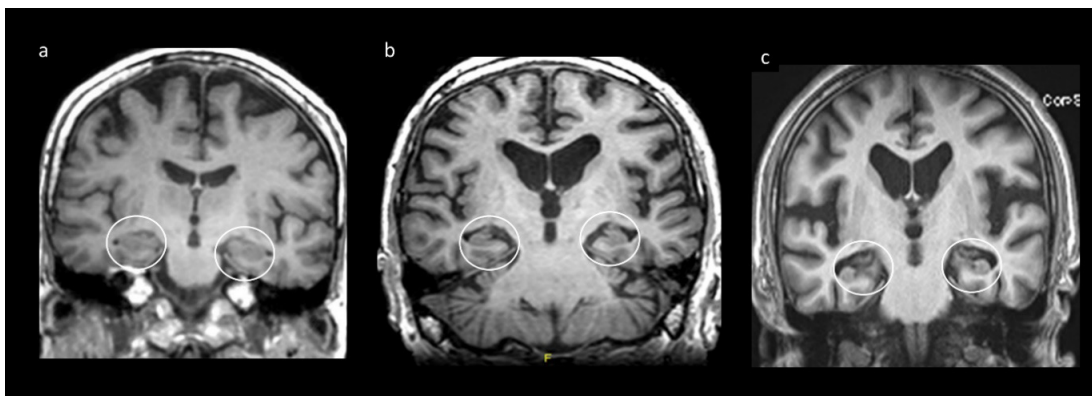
Medial temporal lobe appearances on magnetic resonance imaging in mild cognitive impairment and Alzheimer's disease.
